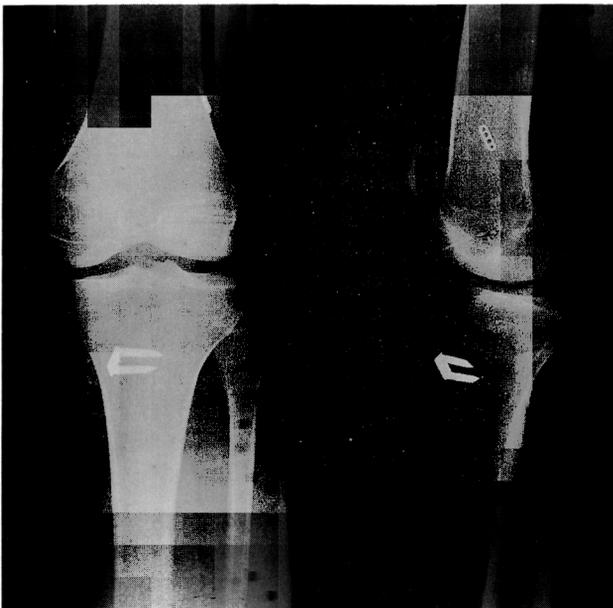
Postoperative radiograph of ACL reconstruction using autogenous hamstring tendon graft without detachment of the tibial insertion.
